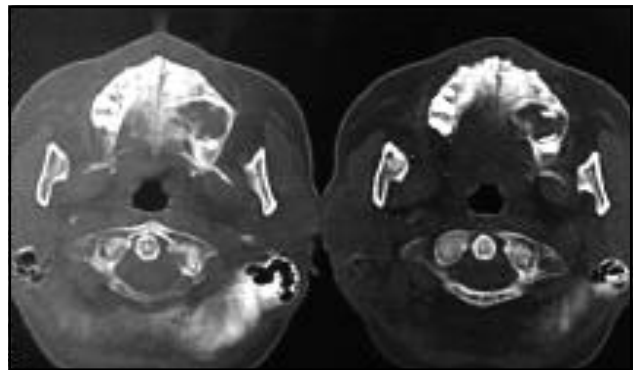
Computed tomography scan of the maxilla; osteolytic area with irregular margins in the left maxilla.
